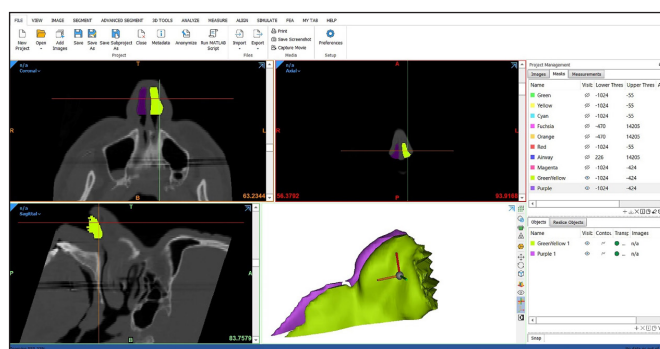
Creation of nasal air passage model from CT images.
